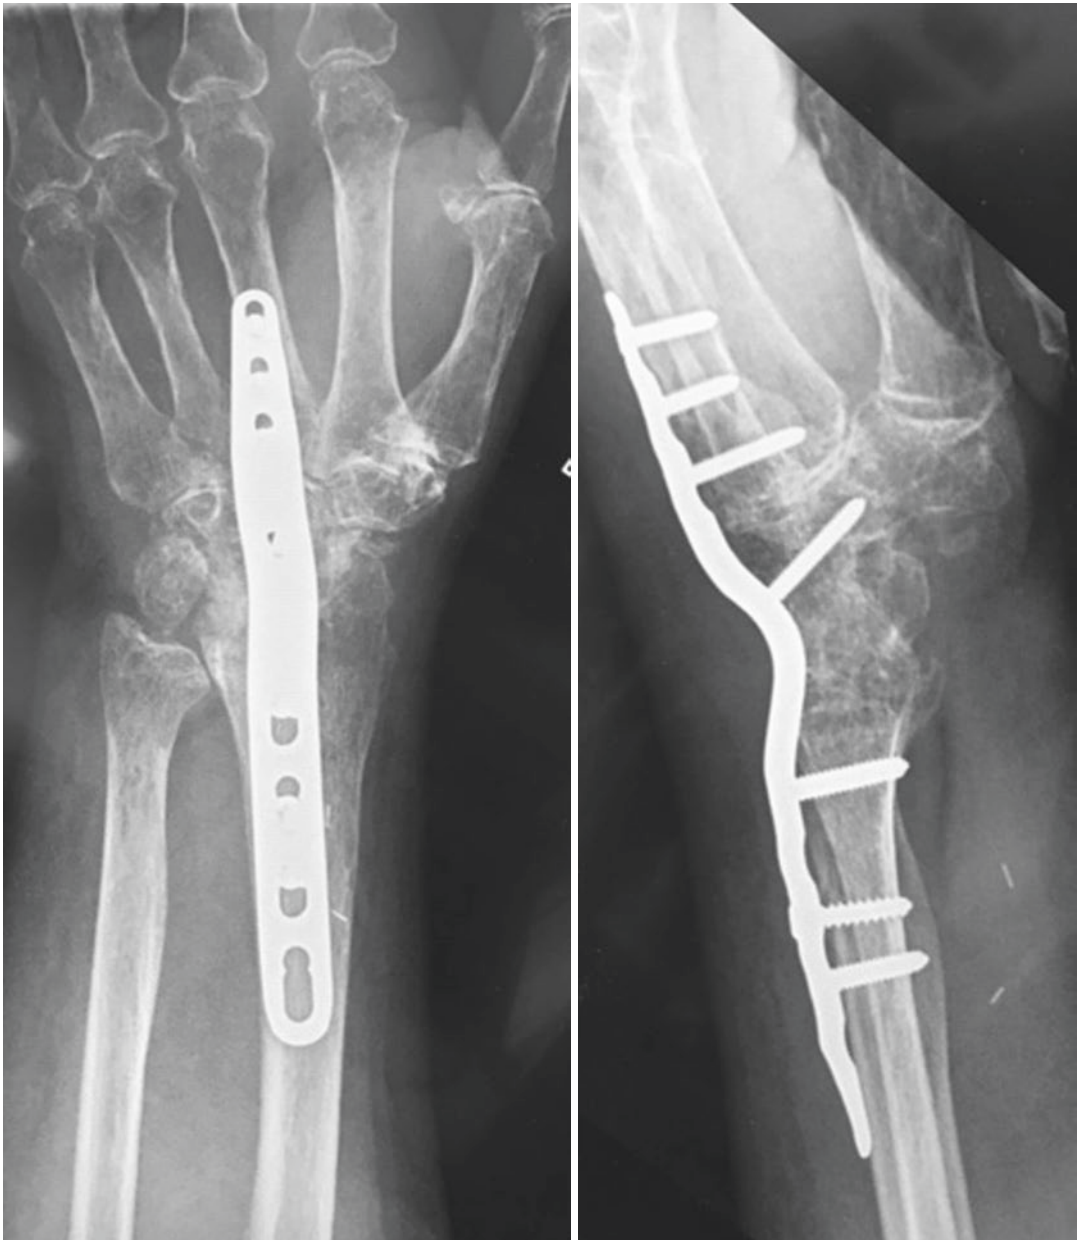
Radiographic evidence of wrist, first CMC joint, and IP joint union by 6 weeks
